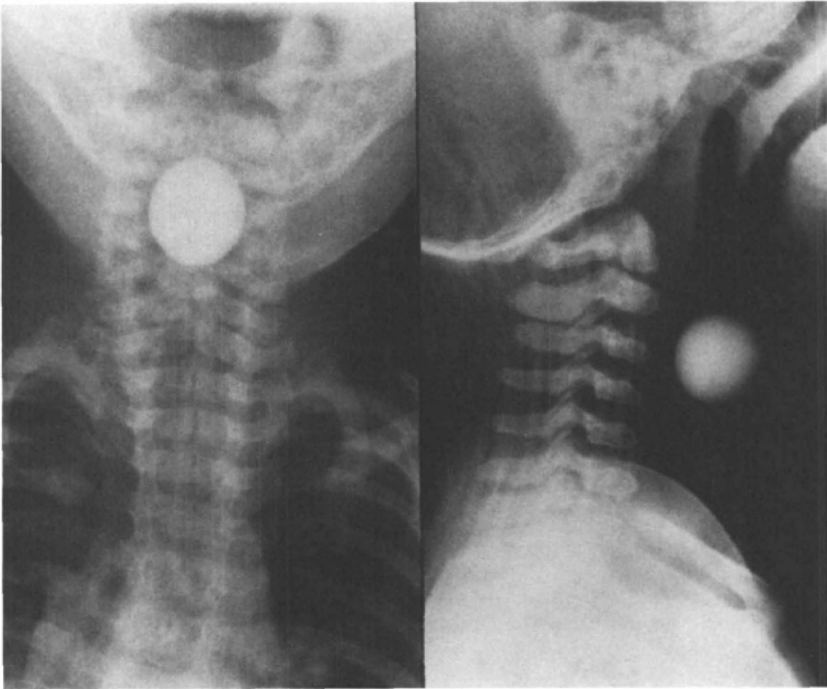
Anterior-posterior and lateral radiographs of an 18-month-old infant who had swallowed a marble. The presence of this oesophageal foreign body caused acute airway obstruction by causing extrinsic compression of the trachea.
